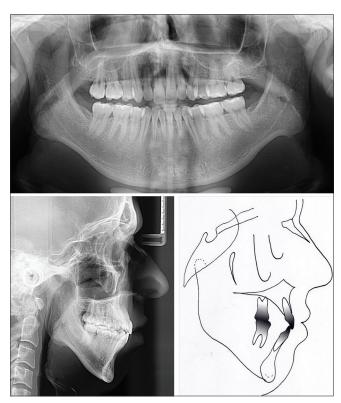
Pretreatment panoramic, cephalometric radiographs and tracing, and cephalometric measurements
